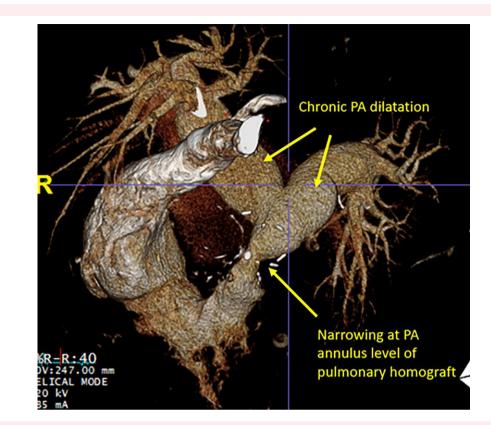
CTA showing narrowed pulmonary homograft.
